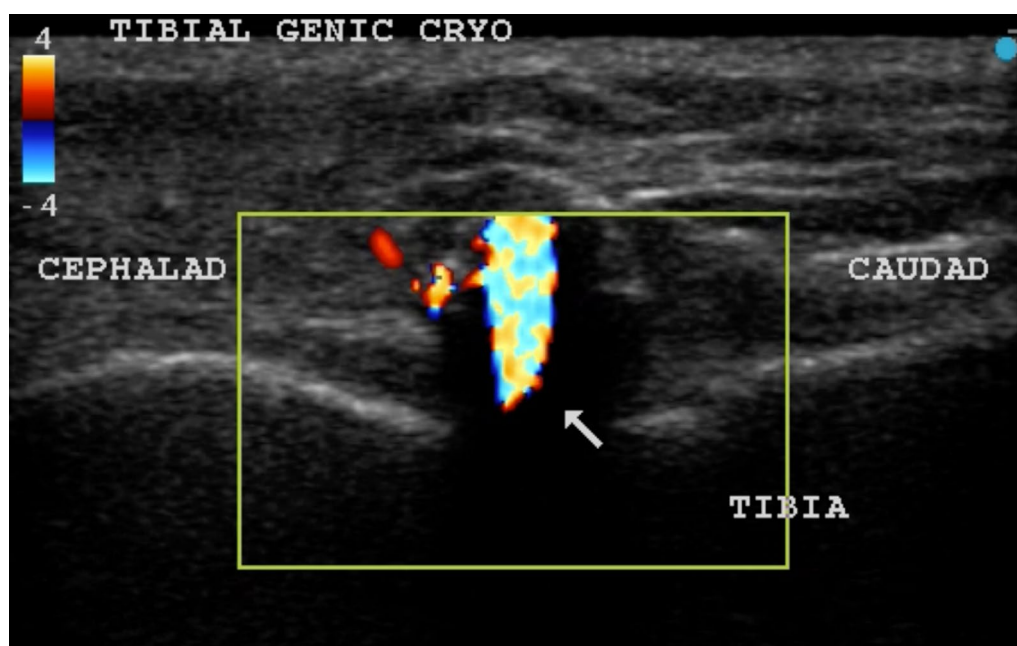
Hypoechoic shadow of the ice is marked by the arrow and the color at the junction of the tibial shaft and condyle. The color doppler picks up on the CO₂ flow
